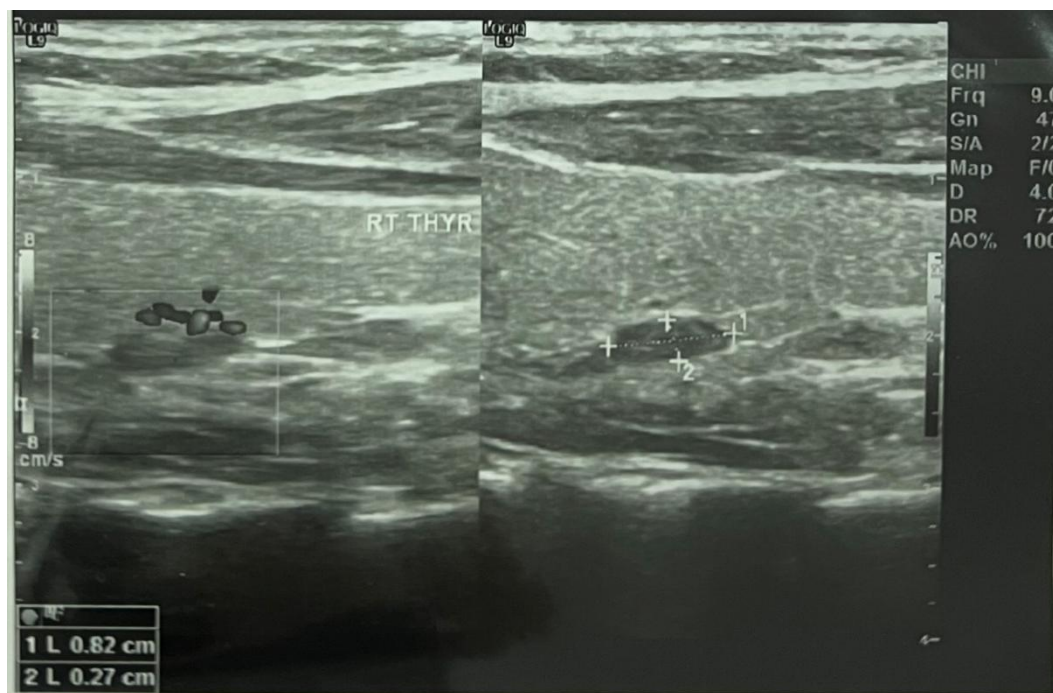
Neck (thyroid) ultrasound, right lobe
